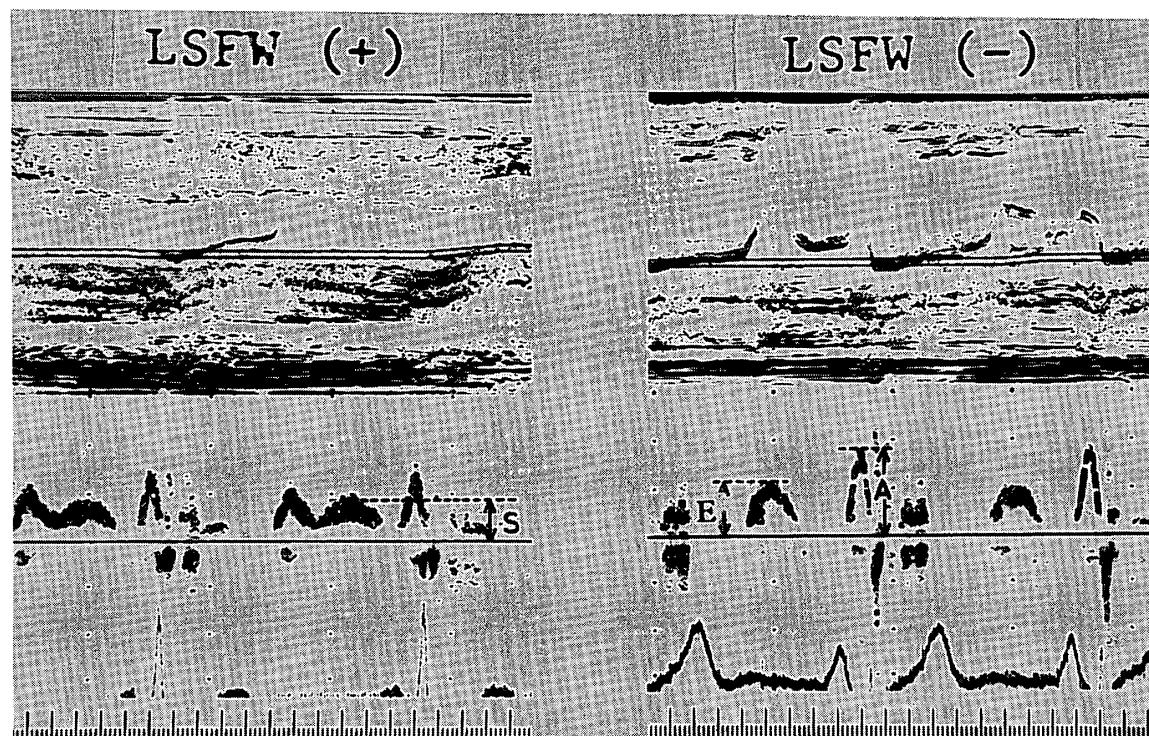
Transmittal flow velocity patterns obtained by pulsed Doppler echocardiography. The left panel shows the transmittal flow velocity pattern with a large slow filling wave (LSFW) and the right panel shows one without any LSFW. E: peak velocity during early filling phase, A: peak velocity during atrial contraction phase, S: peak velocity during slow filling phase.
